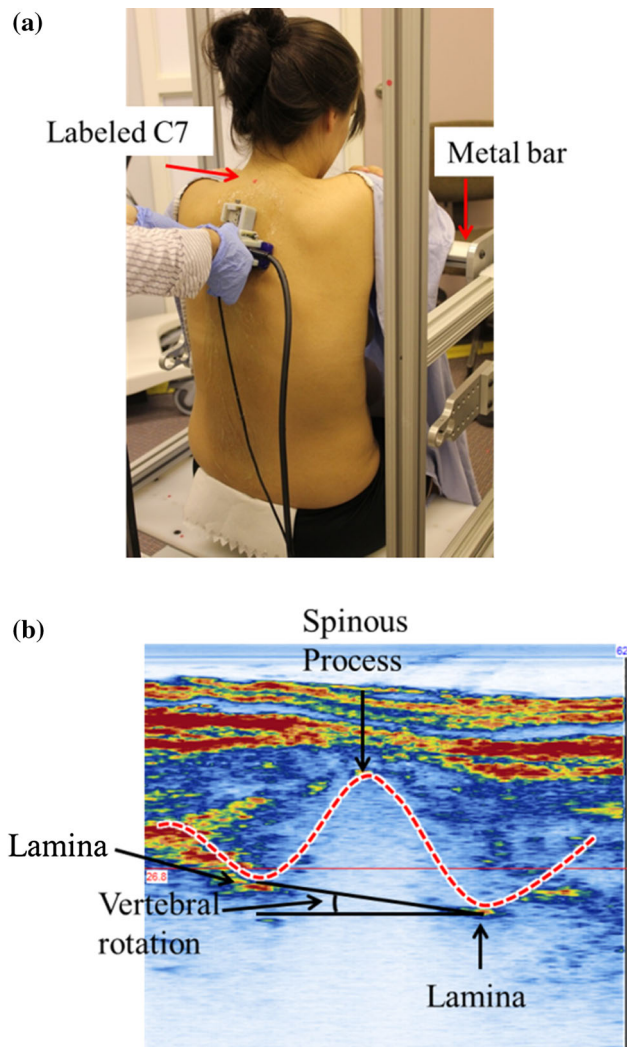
a The set up to scan a subject's back. b An ultrasound transverse image from one of the vertebrae
